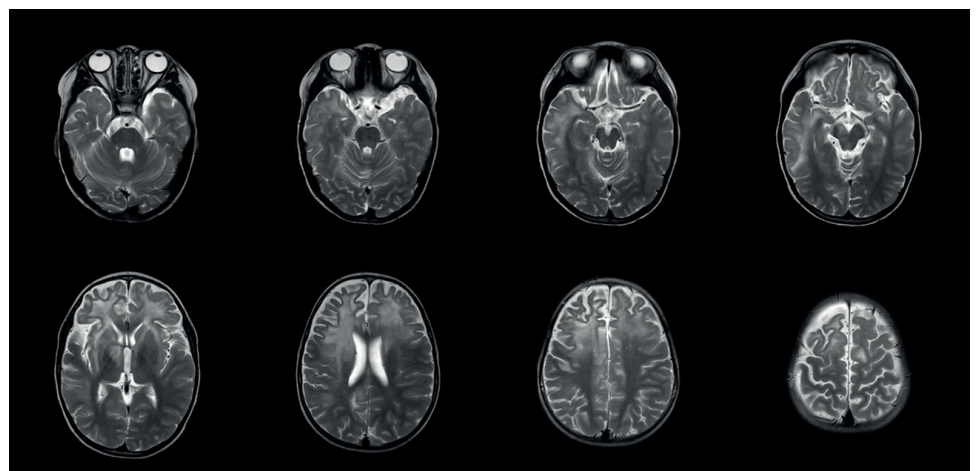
MRI of the brain. T2-weighted MRI shows hyperintensity in the bilateral frontal, temporal, and right parietal white matter, as well as the bilateral basal ganglia, thalamus, and right midbrain. MRI, magnetic resonance imaging.
